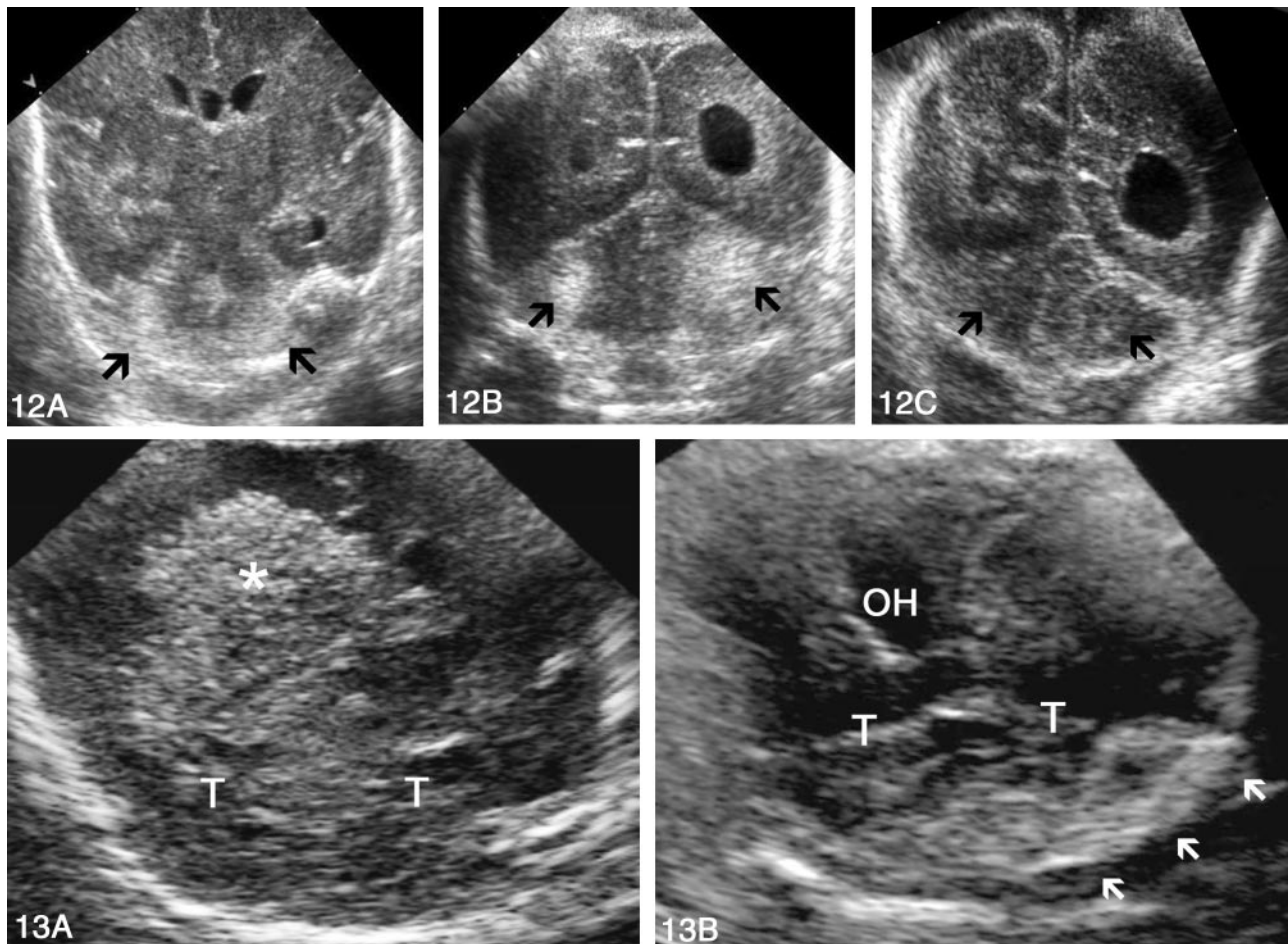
Sonograms of bilateral cerebellar hemorrhage obtained in a neonate without intraventricular hemorrhage at 30 weeks' gestational age.
